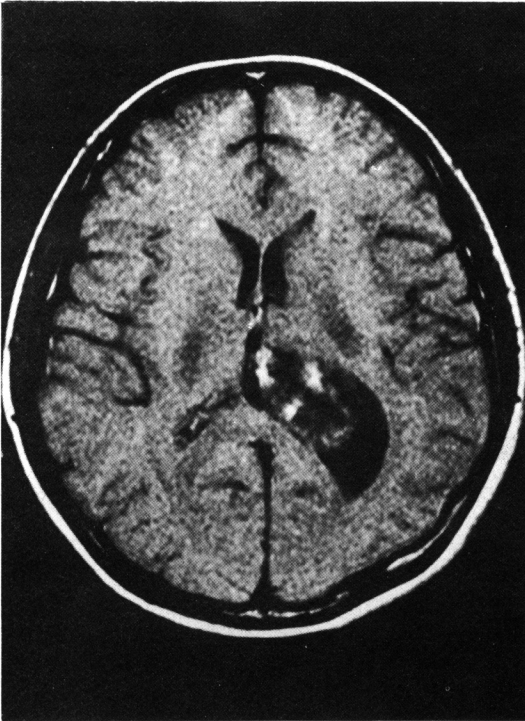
T1-weighted image reveals hypointense signal intensity mass with multiple small high signal intensities at body of the left lateral ventricle.
